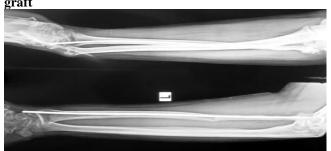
X-ray showing incorporation and union of fibular graft
